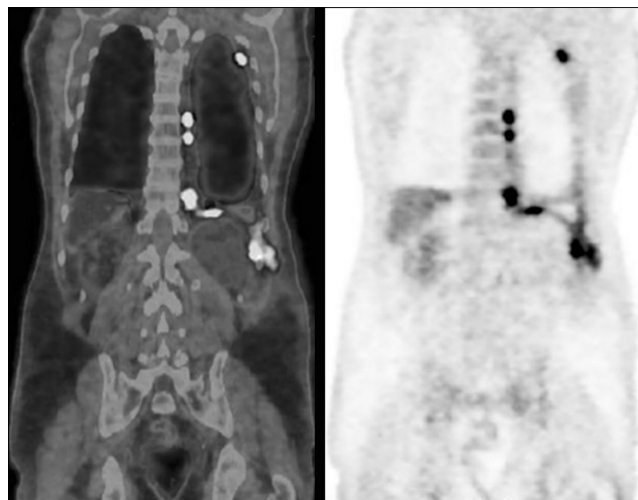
Positron emission tomography scan prior chemotherapy, demonstrating a dispersed hypermetabolic thickening through the left pleura, especially the costodiaphragmatic region, invading the chest wall, and an homolateral pleural effusion with heterogeneous uptake of F-18 fluorodeoxyglucose (SUVmax 10.6).
